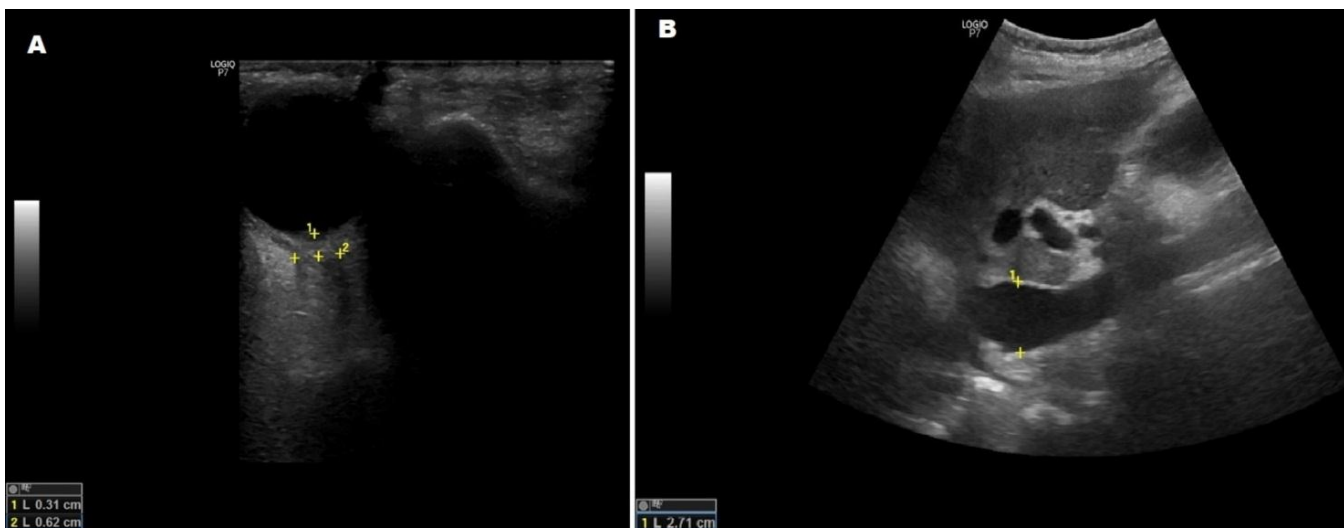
(A) A transverse orbital ultrasound image shows a hypoechoic optic nerve, measured at 6.2 mm, 3 mm behind the posterior globe margin, (B) An abdominal ultrasound image shows a dilated IVC (27 mm) with minimal inspiratory collapse indicating significant fluid overload.
